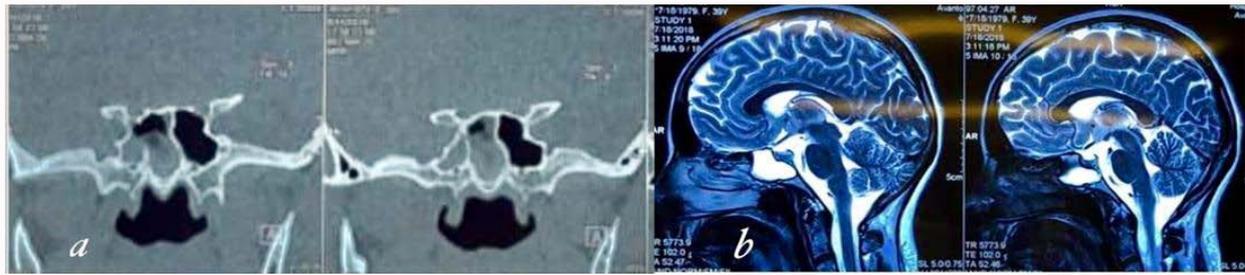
(a) Coronal CT cisternography shows sphenoid sinus filled with CSF. (b) Sagittal T2-weighted MRI of the brain showing Cerebrospinal Fluid (CSF) leak into the sphenoid sinus trough clival defect.
